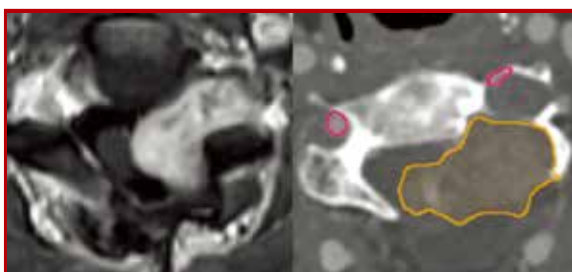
Axial contrast T1 MRI (left) and CTA (right) of recurrent cervical dumbbell neurogenic spinal tumours 3 years after Laminotomy (facet-sparing). The recurrent dumbbell spinal tumour is herniating out from the old laminotomy site and the spinal cord is compressed. (Personal collection)
